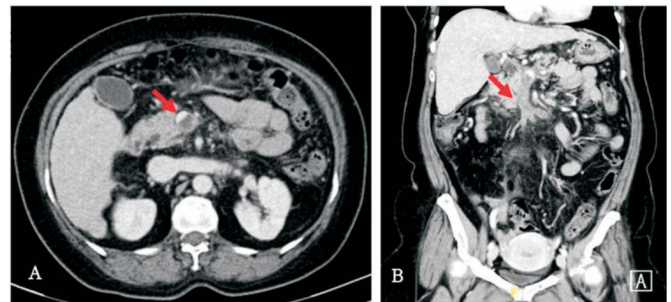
(A and B) Contrast-enhanced CT showing portomesenteric venous thrombosis (Red arrows).
